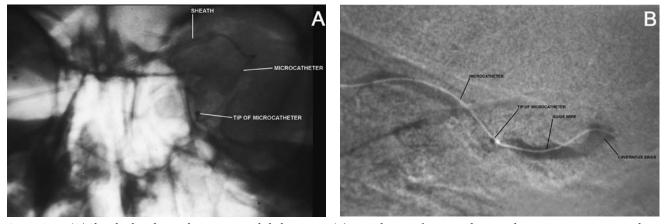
(A) Sheath placed into the superior ophthalmic vein. (B) Lateral view of microcatheter and contrast injection into the superior ophthalmic view and cavernous sinus. Radiographs of a right internal carotid angiogram after placement of a detachable balloon in the cavernous sinus to seal the fistula; the balloon was introduced from the arterial side.
